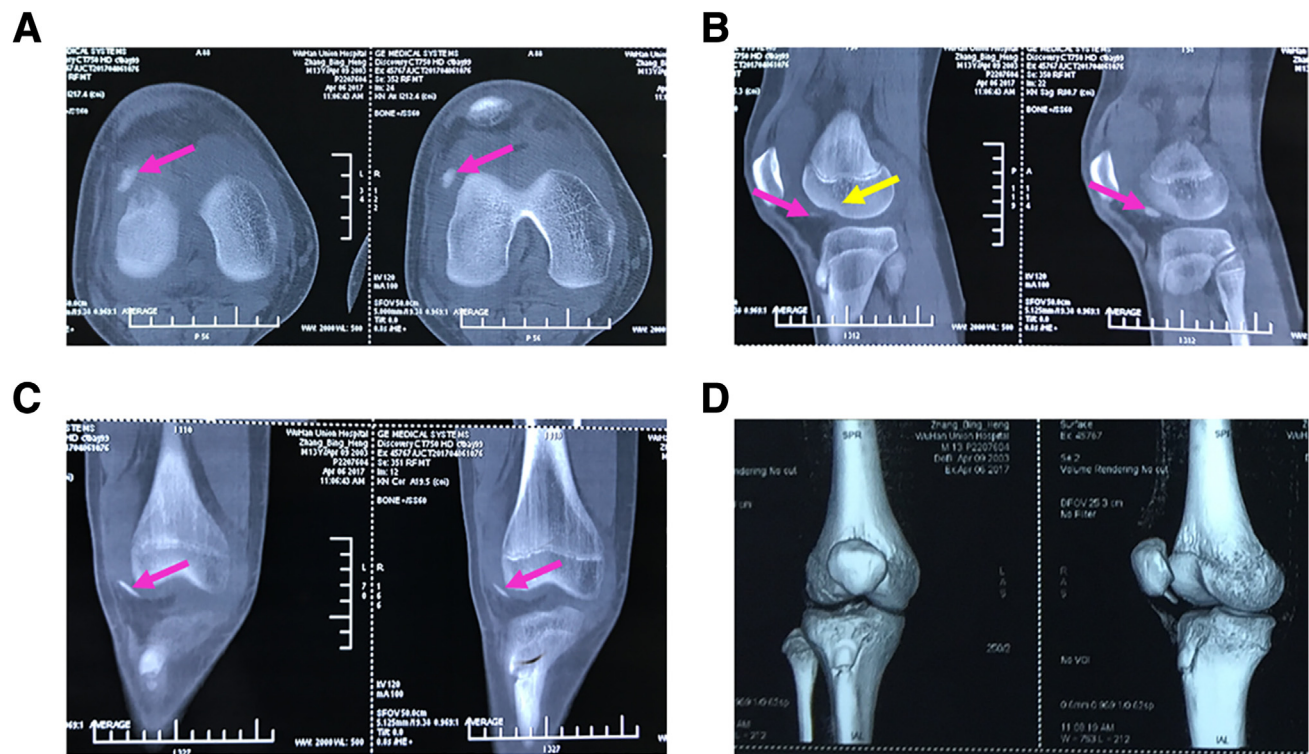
Computed tomography results of the patient before surgery. As shown in this figure, osteochondral injury and free osteochondral fragments of the femoral lateral condyle of the right knee are easily and clearly observed. (A) Cross-section. (B) Sagittal section. (C) Coronal section. (D) Three-dimensional reconstruction. The pink arrow indicates the free osteochondral fragment. The yellow arrow indicates the defect area.
